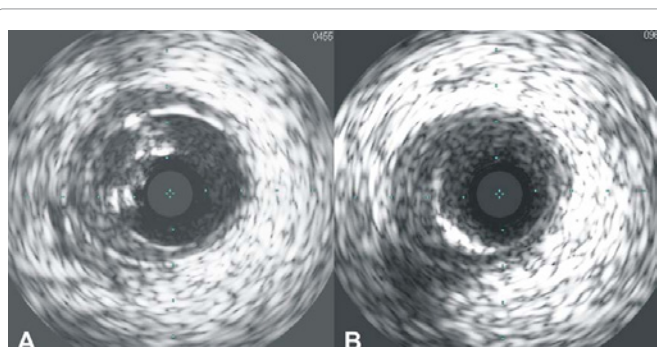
A - Intravascular ultrasound (IVUS) of the RCA following initial stent implantation. The under-deployed struts of the stent and heavy calcium burden are visible. B - IVUS appearance following stentablation. The calcium burden and under-deployed stent struts are no longer visible.
